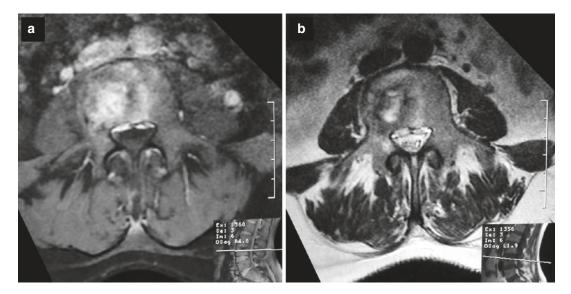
Pott's disease on L4 level with mild intracanalar extension in the same patient as in Fig. 15.2. Axial spinal MRI on T1-weighted image after gadolinium injection (a) and on T2-weighted image (b)
